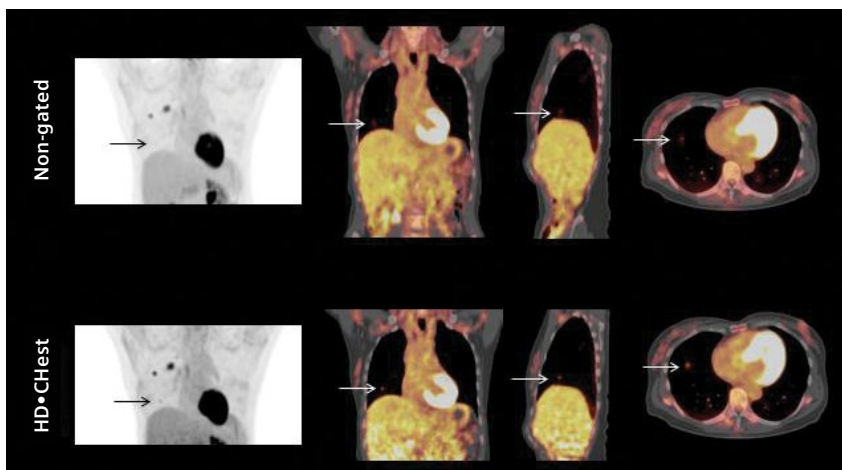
Comparison of MIP and fused PET/CT images of HD•Chest and non-gated reconstructions of the thorax shows improved delineation of a small nodular metastatic lesion in the lower-right lung with HD•Chest (arrow).
